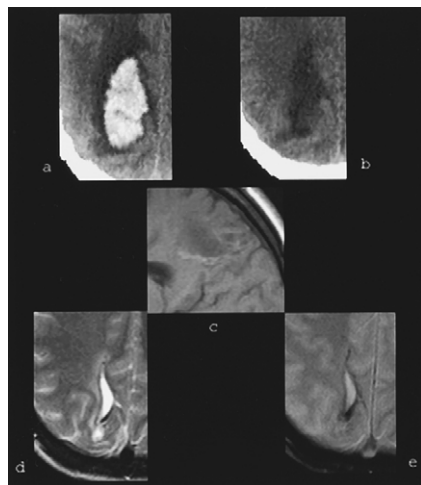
(a) Acute right parietal white matter hematoma caused by an underlying arteriovenous malformation. (b) Follow-up CT shows no sign of hemorrhage. A fluid-filled cavity is seen on MRI with a hemosiderin rim on the T2-weighted (d) and gradient-echo (e) images, consistent with chronic hematoma. (c) A small amount of methemoglobin persists on the T1-weighted image.
